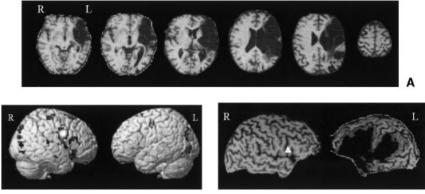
Structural and functional MRI for a mild nonfluent aphasia patient (58-year-old male, 9.5 years poststroke) before rTMS treatment. (A) Structural (axial) MRI scan. (B) Functional MRI scan during overt picture naming before Phase 2 treatment with rTMS. Note the increased activation in right hemisphere perisylvian language regions, especially motor cortex (mouth) and Broca's area (pars triangularis, right BA 45). (C) Left and right lateral views of this patient's brain reconstructed from structural MRI. The triangle marks the posterior gyral portion of right BA 45 (pars triangularis, part of right Broca's area) which was stimulated with the magnetic coil during each 20-minute rTMS treatment session of Phase 2. rTMS, repetitive transcranial magnetic stimulation; BA, Brodmann's area.
